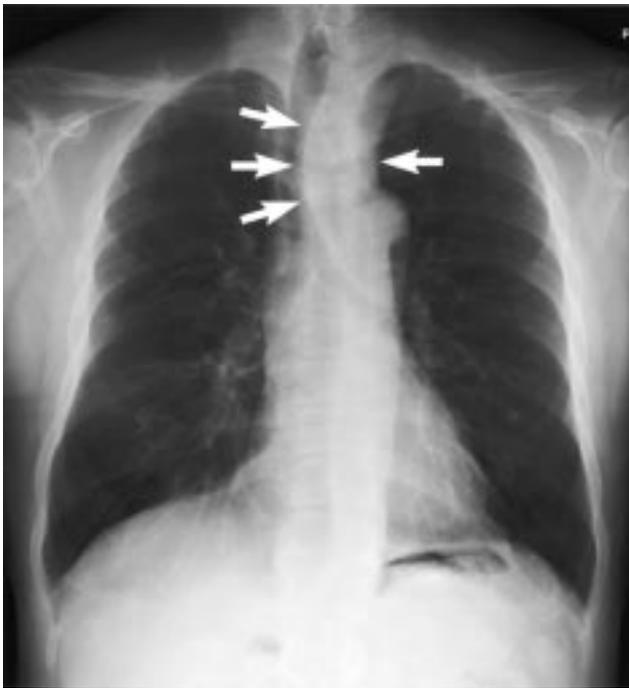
Chest X-ray demonstrated an abnormal mediastinal mass displacing the trachea and a bulge in the left upper mediastinum (arrows).
